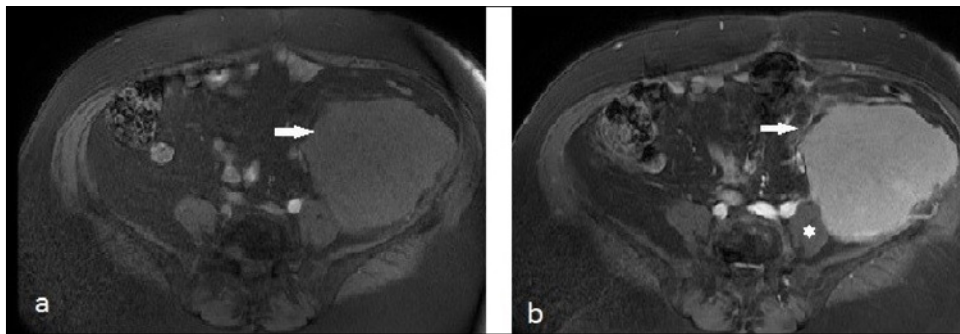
A. Intense contrast enhancement is observed in fat-suppressed T1-weighted pre- (B) and post-contrast MRI series.
